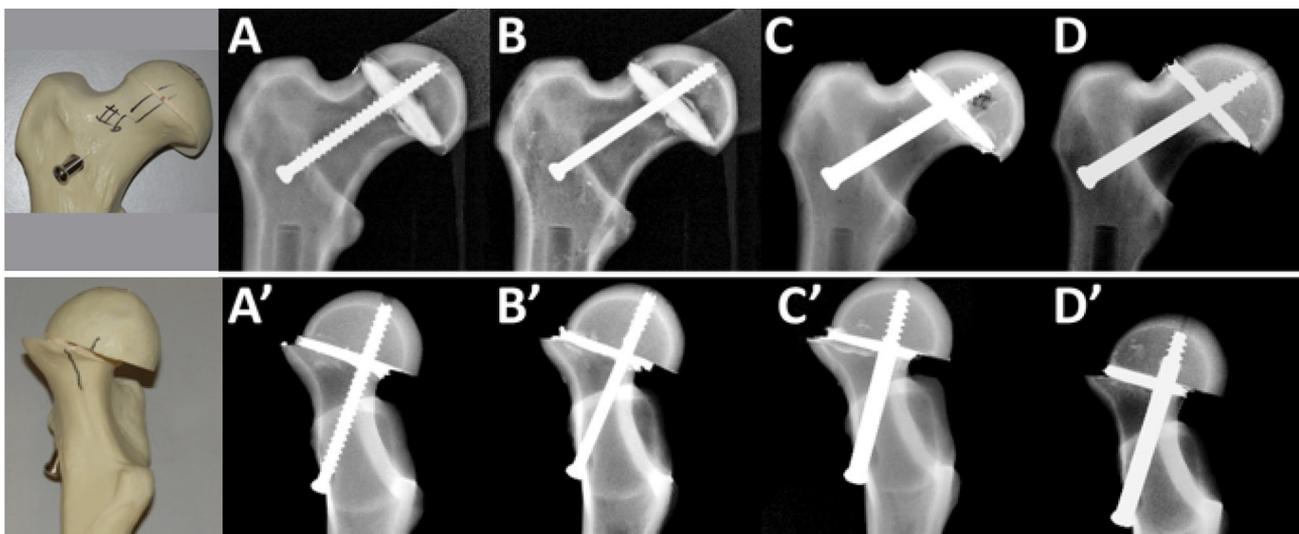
Anteroposterior and lateral picture and radiographs of the saw-bone model with different types of fixation. (a) 6.5 Synthes cannulated screw fully threaded, (b) 6.5 Synthes cannulated screw partially threaded 16 mm, (c) 7.3 Synthes SCFE Screw System partially threaded 20 mm, (d) 7.3 Synthes SCFE Screw System partially threaded 10 mm.
